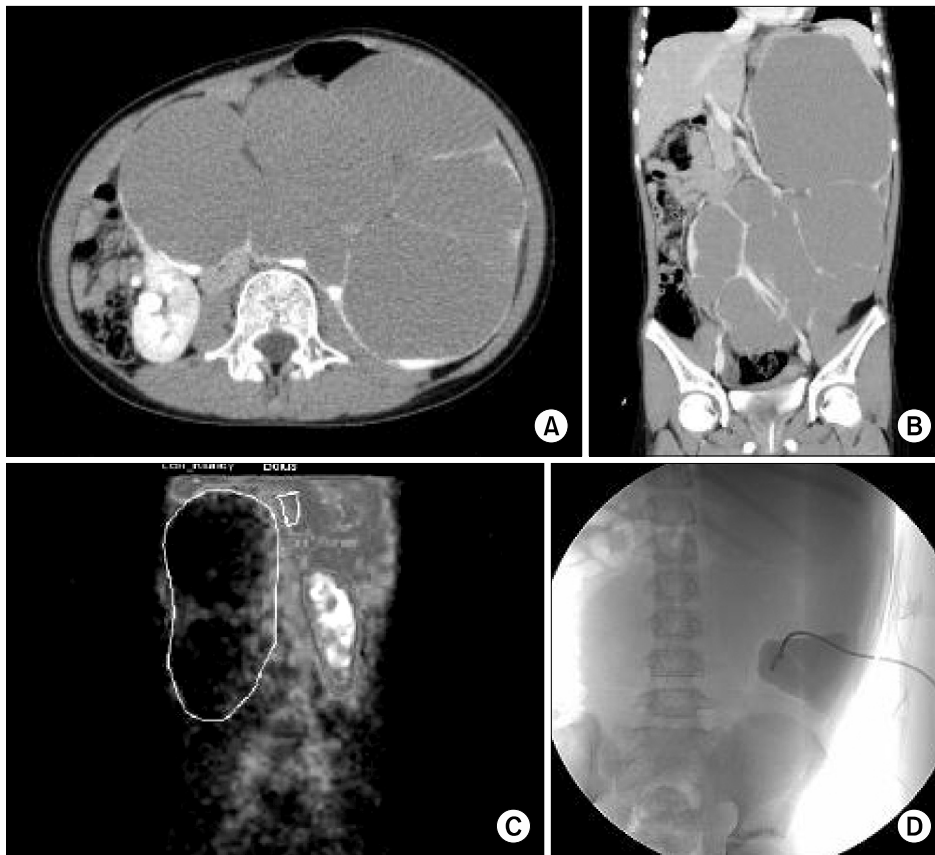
Imaging studies. (A) and (B) enhanced computed tomography scan, transverse and coronal images, showing a horseshoe kidney with very large hydronephrosis of the left kidney. (C) The ^{99m}Tc -MAG3 renal scan showed decreased renal uptake. (D) Insertion of a percutaneous nephrostomy was performed to reduce the size of the hydronephrosis and mark the site so that it could be easily seen during the operation.
